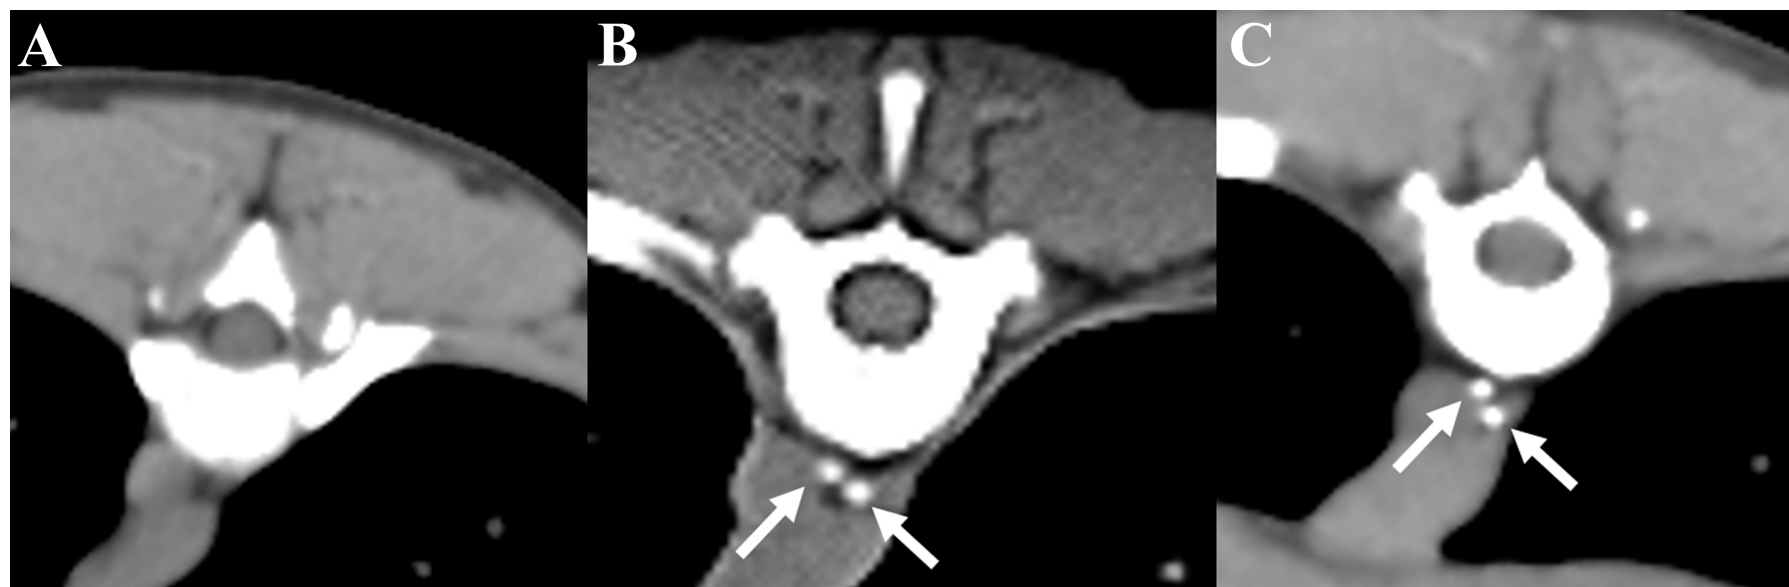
Transverse CT images at the level of T8 at the dose of 0.5 (A), 0.75 (B), 1.0 ml/kg (C), 5 minutes after injection. The thoracic duct was not enhanced after injection of 0.5 ml/kg (A). The attenuation of the left branch of the thoracic duct (arrows) was 381 HU and 614 HU (C).
